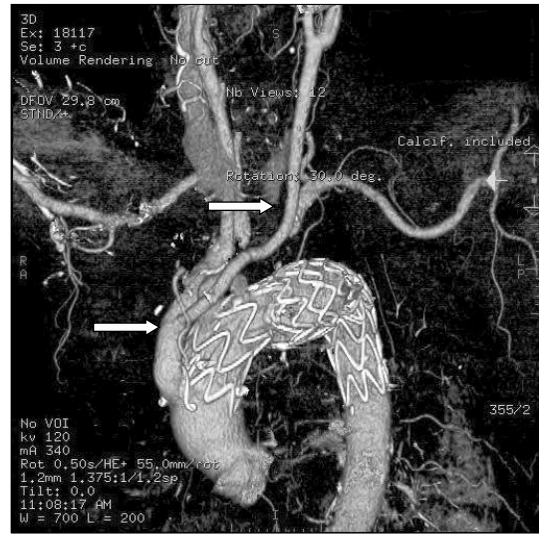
Three-Dimensional reconstruction of MDCT image after hybrid TEVAR. The arrows indicate de-branched innominate artery and left common carotid artery. MDCT=Multi-detector computed tomography; TEVAR=Thoracic endovascular aortic repair.
